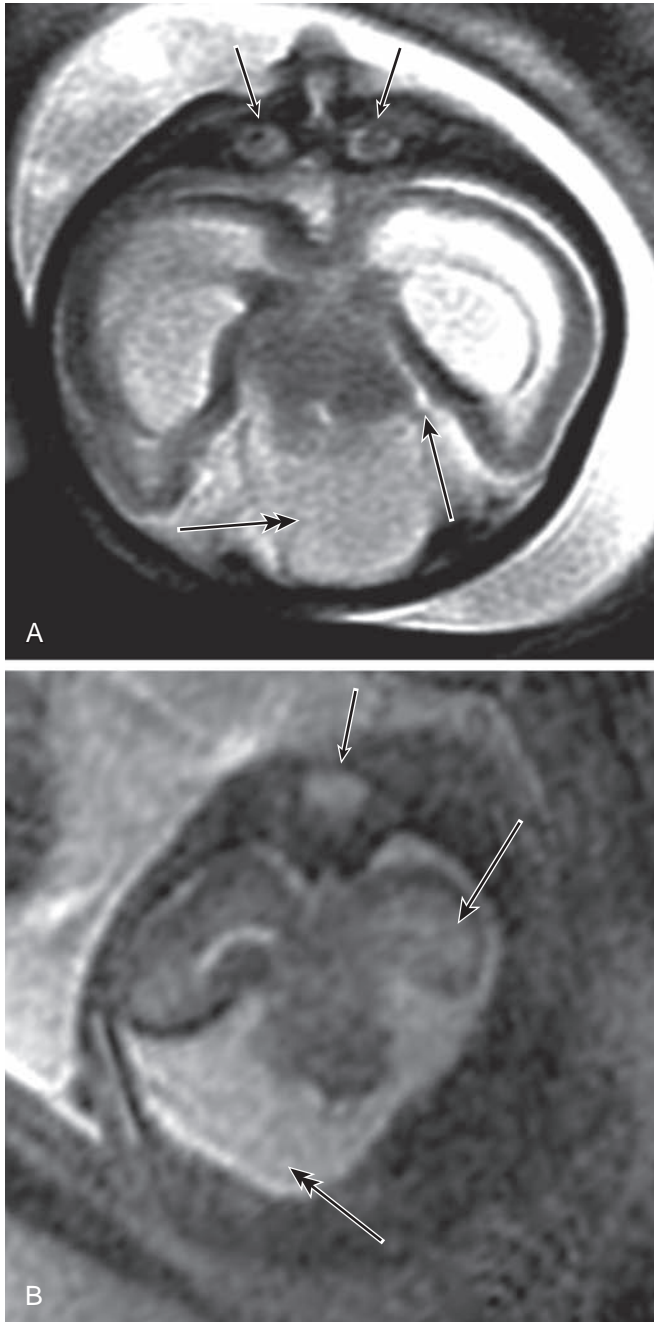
Holoprosencephaly. (A) Axial fetal MRI shows severe hypotelorism and micropthalmia (*small arrows*). A dorsal interhemispheric cyst is present (*double arrow*), and the hippocampus touches the brainstem at the ambient cistern (*long arrow*) in keeping with lobar holoprosencephaly. (B) Axial fetal MRI shows a single small midline globe (*small arrow*). The hippocampus is not touching the brainstem (*long arrow*), and wide communication of the ambient cistern with the dorsal interhemispheric cyst is present (*double arrow*) in keeping with alobar holoprosencephaly. (From Robinson AJ, Blaser S, Toi A, et al. *Magnetic resonance imaging of the fetal eyes—morphologic and biometric assessment for abnormal development with ultrasonographic and clinicopathologic correlation*. *Pediatr Radiol*. 2008;38:971–981.)
